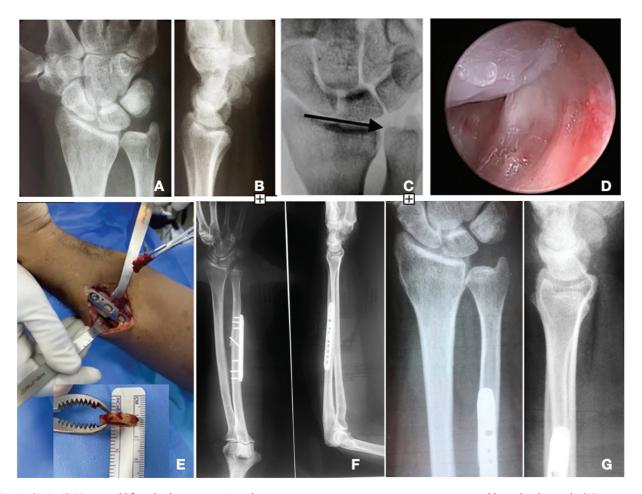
(A, B, C) 53- year old female showing positive ulnar variance on a preoperative anteroposterior and lateral radiograph. (D) wrist arthroscopy (3-4 portal view) findings of a sinlflammetry aspect of triangular fibrocartilage complex and chondromalacia in the ulnar border of the lunate in ulnar impaction syndrome. (E) Intraoperative aspects of the ulna plate position and bone resection. (F) An anteroposterior and lateral radiograph was made after ulnar shortening osteotomy alone and fixation with a specific ulna shortening plate system and screw. (G) A 12month final follow-up anteroposterior and lateral radiograph.
